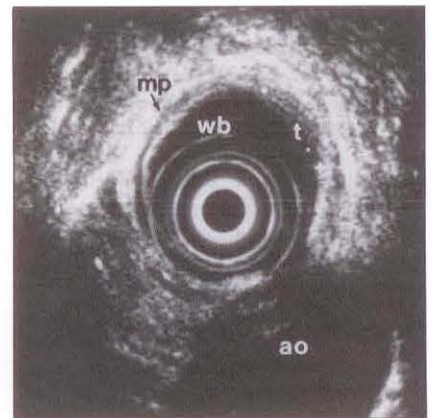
Endosonogram of a small intramural esophageal carcinoma (t) penetrating into the muscularis propria (mp) localized ventrally. wb Water-filled balloon; ao Aorta
